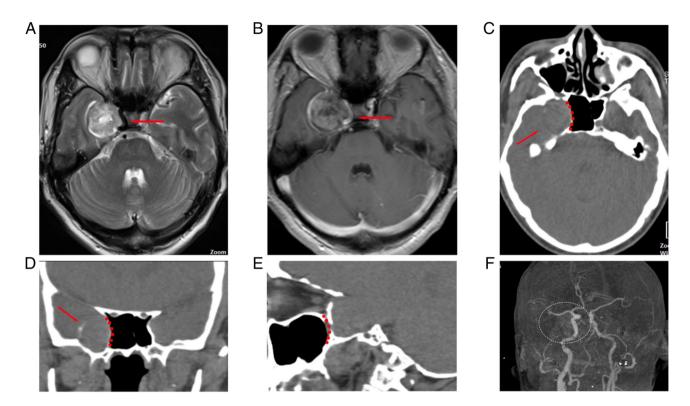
Pre-operative imaging of a TS located in the right middle cranial fossa. (A) Transverse section of the T2-weighted image indicated the position of the TS and the red arrow indicates the flow void in the ICA, which was suppressed by TS. (B) Enhanced transverse section of magnetic resonance imaging showed the direct relationship between the TS and ICA (red arrow indicates the ICA enhanced by contrast agent). (C) Transverse section of the CT scan showed the relationship among the TS, the posterior wall of the maxillary sinus and the lateral wall of the sphenoid sinus (red dotted line represents the lateral wall of the sphenoid sinus; red arrow indicates the eggshell calcification). (D) Coronal section of the CT scan showed that the TS was closely adjacent to the lateral wall of the sphenoid sinus and the red arrow indicates eggshell calcification). (E) Sagittal section of the CT scan showed that the TS was closely adjacent to the posterior wall of the maxillary sinus (red dotted line represents the lateral wall of the maxillary sinus). (F) Cerebral angiography showed that cerebral vessels were in a normal state excluding vascular abnormalities. (white dotted zone indicates the position of the tumor). CT, computed tomography; ICA, intracranial carotid artery; TS, trigeminal schwannoma.
